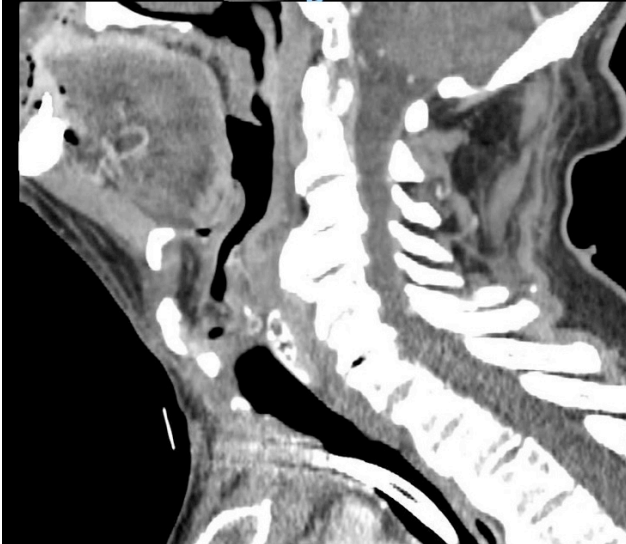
MRI Scan of the neck
